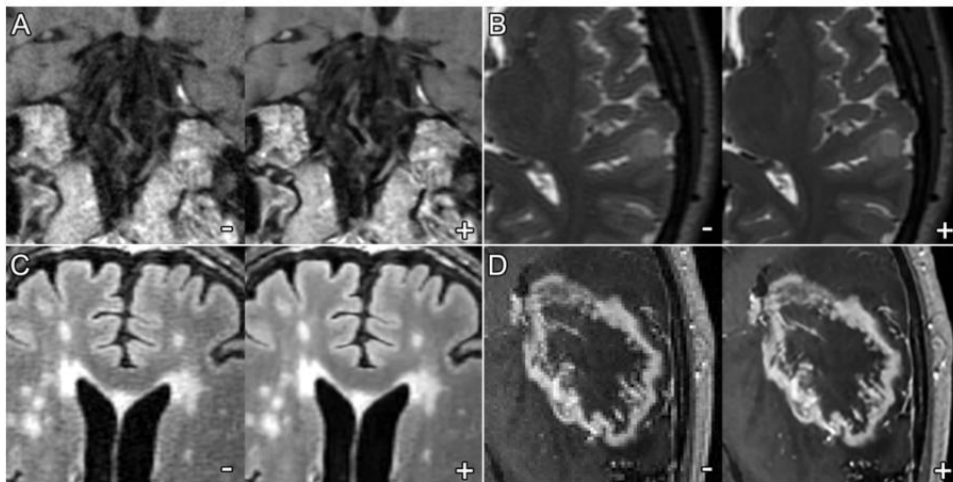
Side-by-side comparison of brain pathology using conventional (-) versus AIR recon DL (+) reconstruction of 3D MRI data acquired using 4 different sequences: (A) coronal T1 black-blood postcontrast (arterial wall imaging) of a patient with diffuse atherosclerotic vasculopathy of the basilar artery; (B) axial T2 fat saturated imaging of a patient with a non-enhancing cortically based tumor in the left posterior temporal lobe; (C) axial T2 FLAIR imaging of a patient with leukoaraiosis; (D) axial T1 fast gradient echo postcontrast imaging of a patient with a left frontoparietal glioblastoma.
